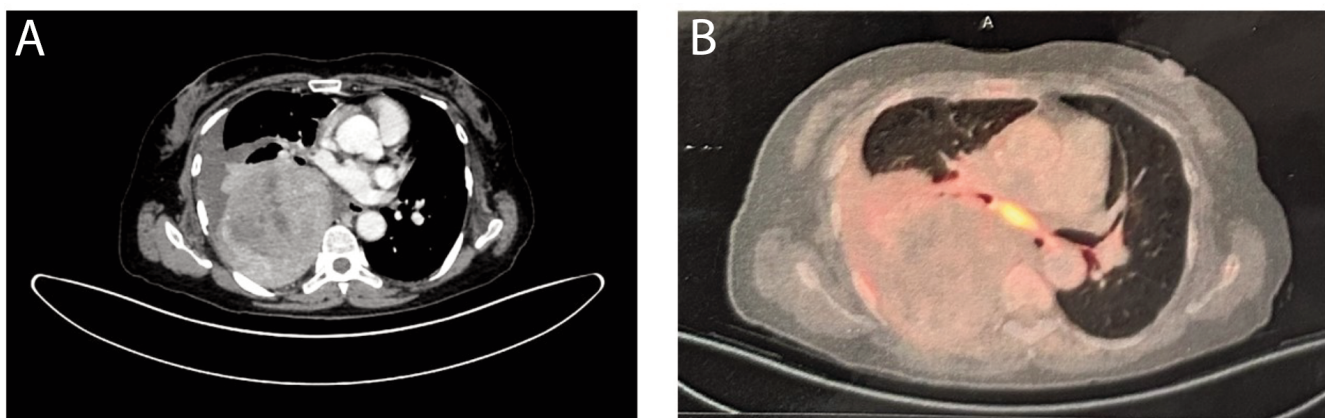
Positron Emission Tomography Computerized Tomography (PET CT) shows a mildly Fluorodeoxyglucose (FDG)-avid (Standardized Uptake Value, SUV, max 4.1) heterogeneously enhancing pleural-based soft tissue mass lesion with areas of internal necrosis, measuring 10.2x8.2x12.3 cm.
